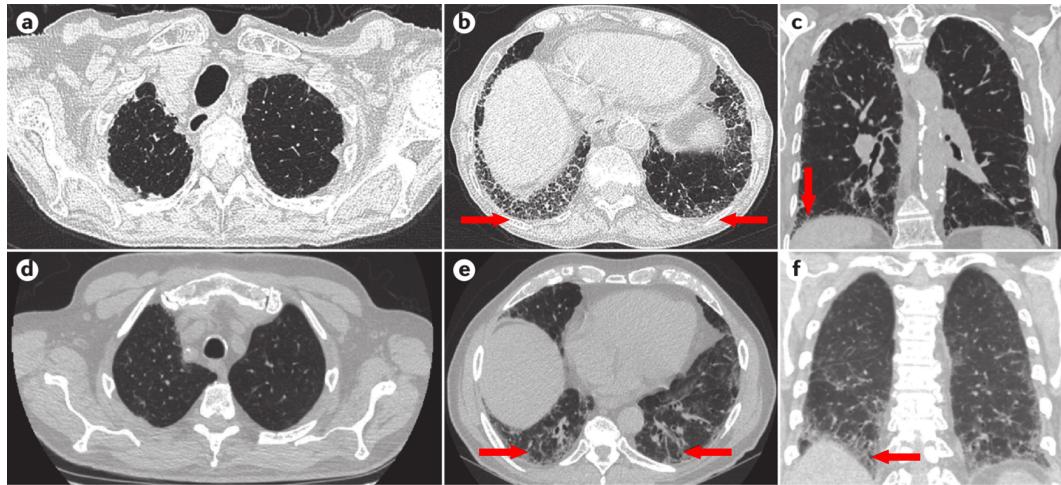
HRCT images of UIP pattern from two patients. The first is from a woman with progressive cough and dyspnoea, showing her upper (a), lower (b) lung zones and ~~a-~~the sagittal plane of the lungs (c). These images show lower lobe-predominant peripheral honeycomb change (b and c, arrows), which is typical of UIP pattern. This patient had no systemic disease or exposures that would exclude idiopathic disease, the diagnosis of IPF is certain. By contrast, the second is a woman with progressive breathlessness, could be diagnosed with possible IPF. The upper (d), lower (e) lung zones and sagittal image of the lungs (f) demonstrate ~~X~~ peripheral, basilar-predominant, reticular densities with traction bronchiectasis (e and f, arrows) consistent with fibrosis. Surgical lung biopsy is suggested. Reproduced from (Martinez et al., 2017))
